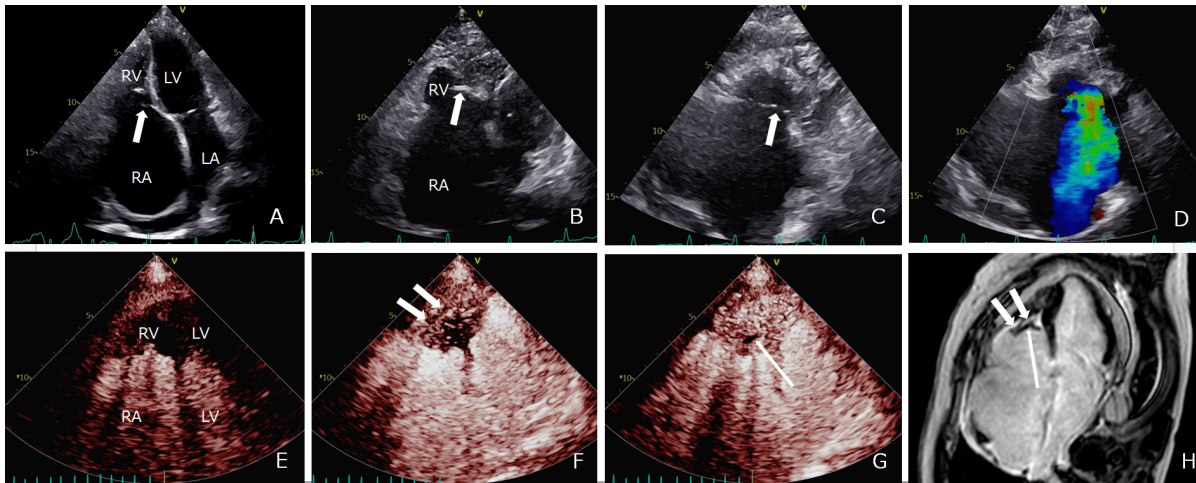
RV-EMF patient. (A) Apical 4-chamber view during systole showed significant RA enlargement and downward traction on tricuspid valve septal leaflet (arrow). (B) RV shrinkage and deformation, RV apical occlusion, and thrombus calcification (arrow). (C,D) Right ventricular inflow tract view shows the fissure when tricuspid valve is close (arrow), and severe TR. (E–G) They are MCE images after high-energy pulse flash, which are the first cardiac cycle, the third cardiac cycle, and the plateau phase, respectively. Perfusion in the myocardium of the occlusion site was normal (short arrows), perfusion in the TFE was delayed, and perfusion in the uncalcified thrombus was absent (long arrow). (H) CMR late gadolinium enhancement TFE showed typical “V sign” (short arrows). The black area was the thrombus (long arrow). RV, right ventricle; RA, right atrium; TR, tricuspid regurgitation; MCE, myocardial contrast echocardiography; TFE, thickened fibrotic endomyocardium; CMR, cardiac magnetic resonance imaging; LV, left ventricle; LA, left atrium; EMF, endomyocardial fibrosis; RV-EMF, right ventricular endomyocardial fibrosis.
